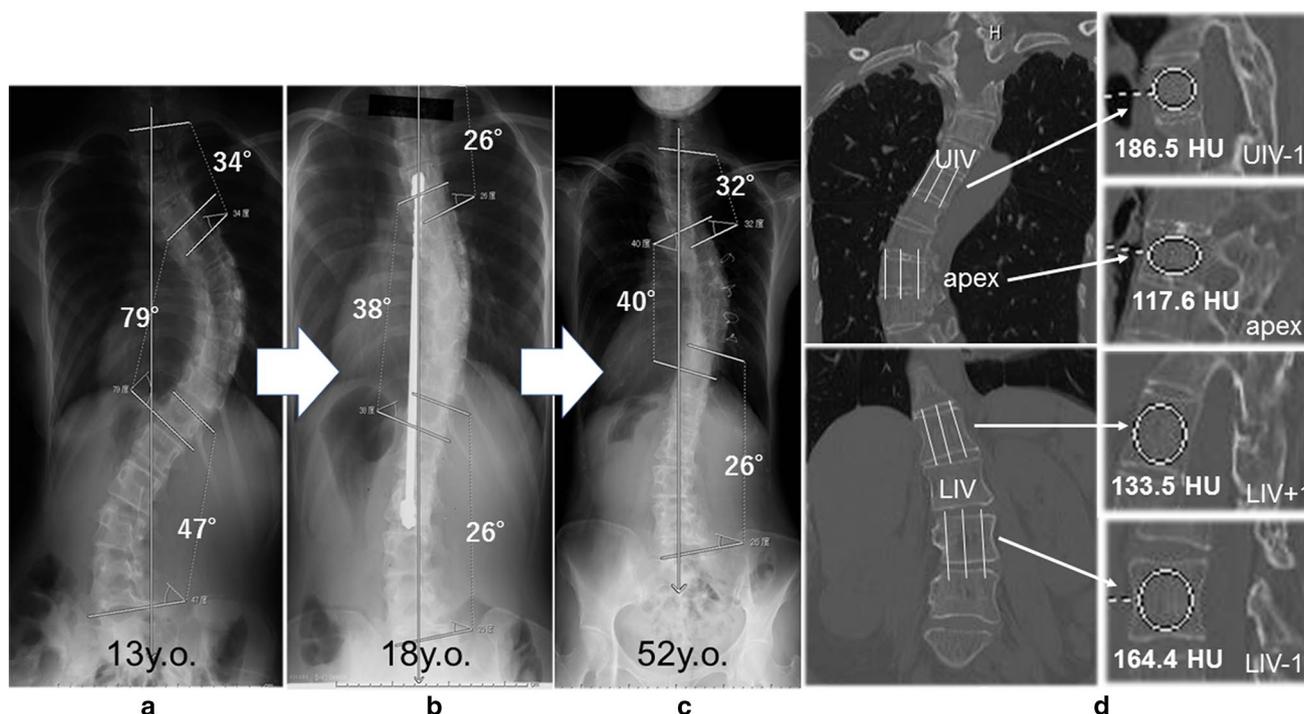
a Radiograph of a 13-year-old girl with Lenke type 2 adolescent idiopathic scoliosis before surgery. b Radiograph 5 years after posterior spinal fusion using Harrington instrumentation from T4 to L2. c Radiograph 34 years after implant removal, demonstrating acceptable correction. d CT scans showing the determination of the HU value using an elliptical region-of-interest function: (left) sagittal planes of interest on the coronal slices of the whole-spine CT scan;
